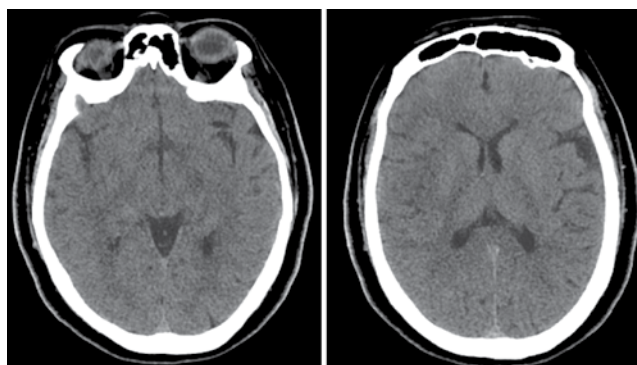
CT of the brain of patient F. One day before admission to the RSC
